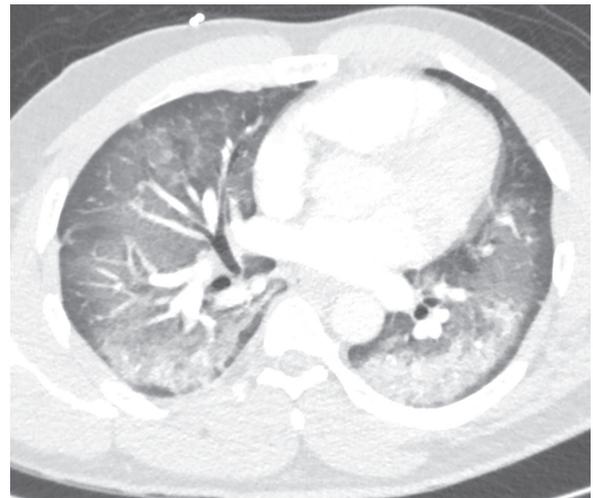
Computed tomographic angiography revealing widespread bilateral ground glass opacities.
